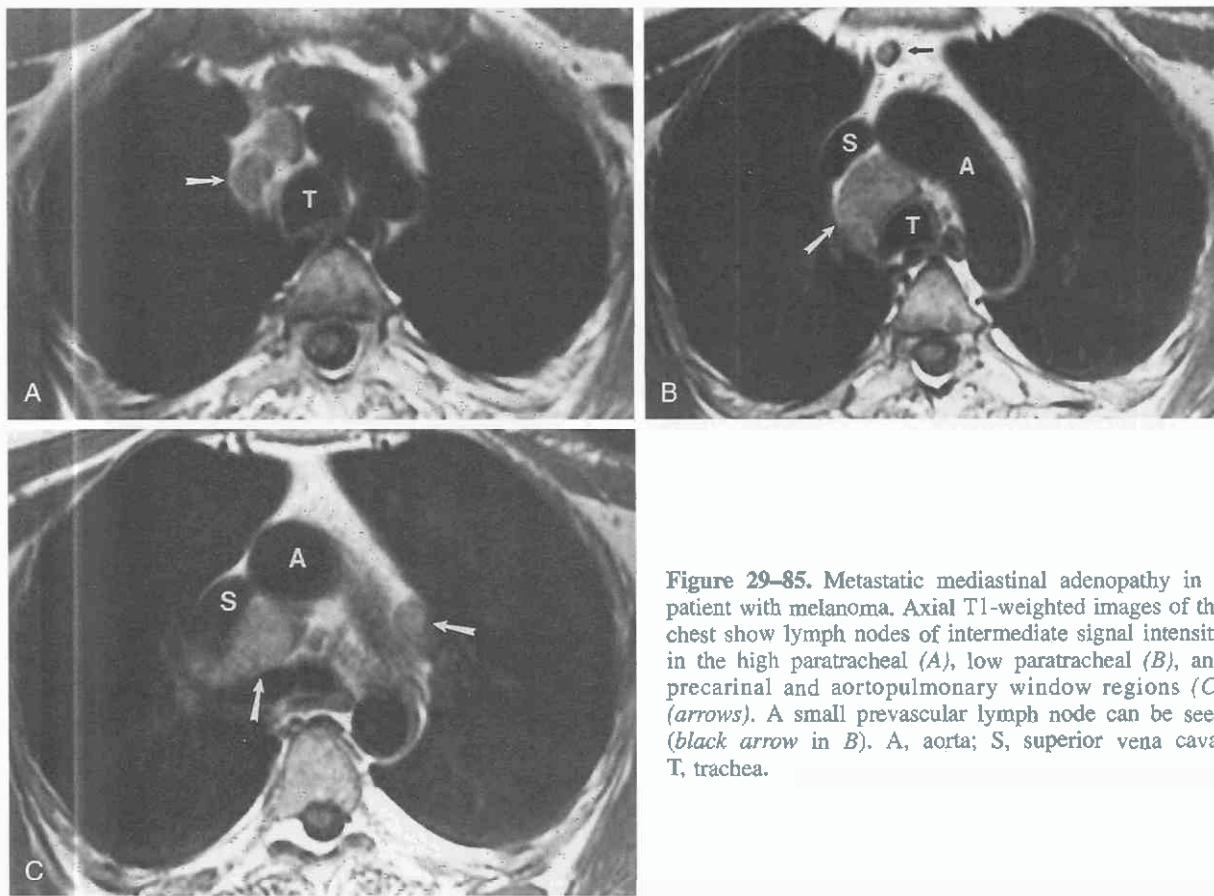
Metastatic mediastinal adenopathy in a patient with melanoma. Axial T1-weighted images of the chest show lymph nodes of intermediate signal intensity in the high paratracheal (A), low paratracheal (B), and precarinal and aortopulmonary window regions (C) (arrows). A small prevascular lymph node can be seen (black arrow in B). A, aorta; S, superior vena cava; T, trachea.
